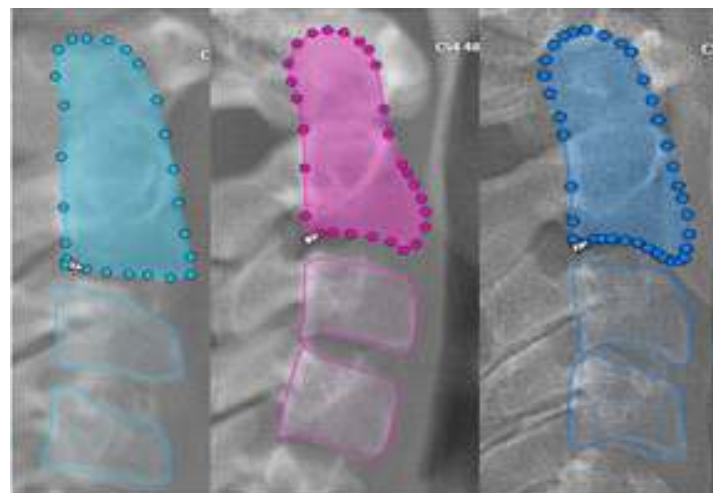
It shows an artificial intelligence-based algorithm for cervical vertebrae maturation stage assessment where AI algorithms are used to automatically identify and outline cervical vertebrae (C2–C4) on lateral cephalometric radiographs. By analyzing the shape and size of these bones, the AI accurately determines the patient's skeletal maturation stage, helping orthodontists plan growth-related treatments more objectively and efficiently.
